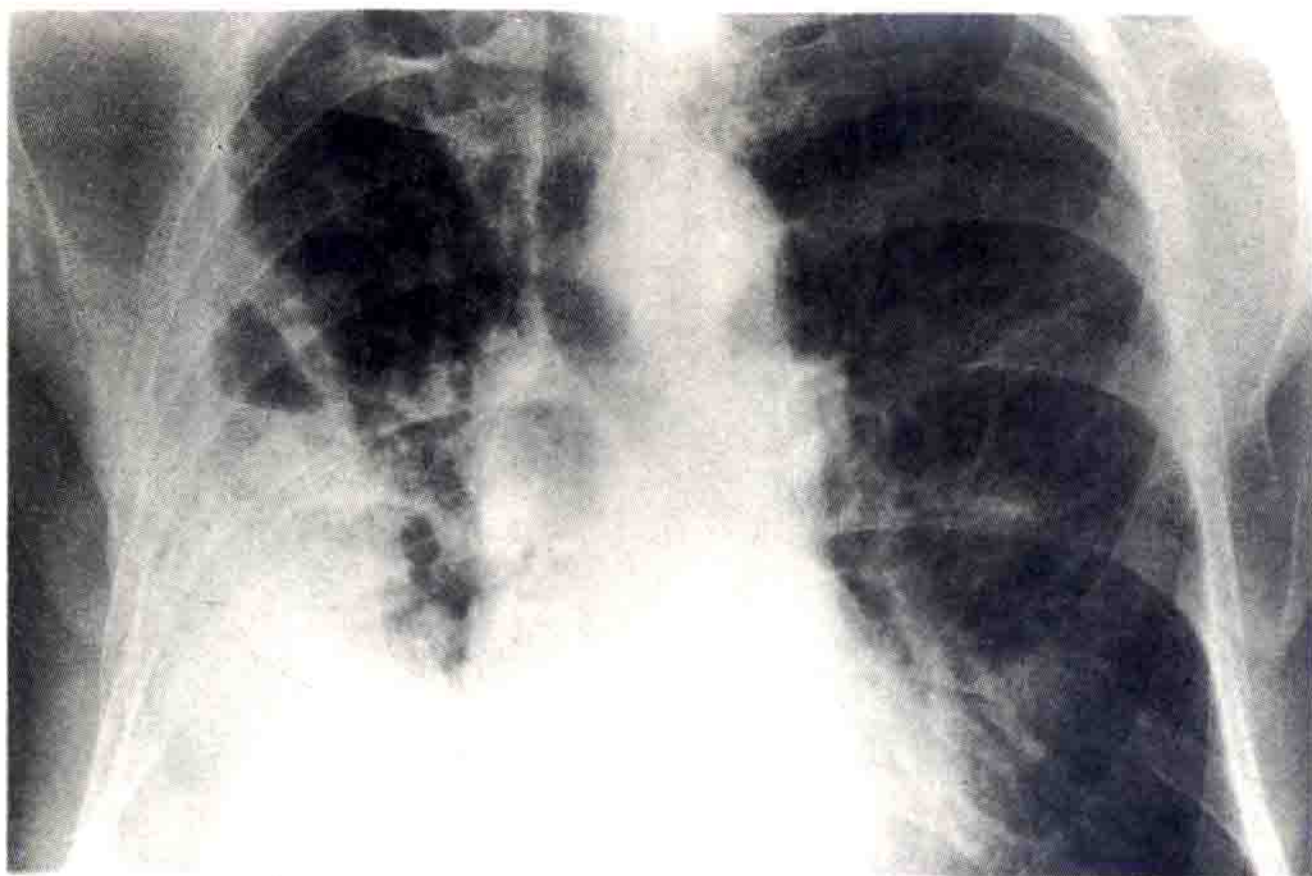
Empyema. Transient pleural effusion is common in pneumonia and sometimes the effusion becomes purulent. This radiograph shows a large right pleural effusion with an air-fluid level. This pyopneumothorax or hydropneumothorax could result from insertion of air during aspiration or from the formation of a bronchopleural fistula.
